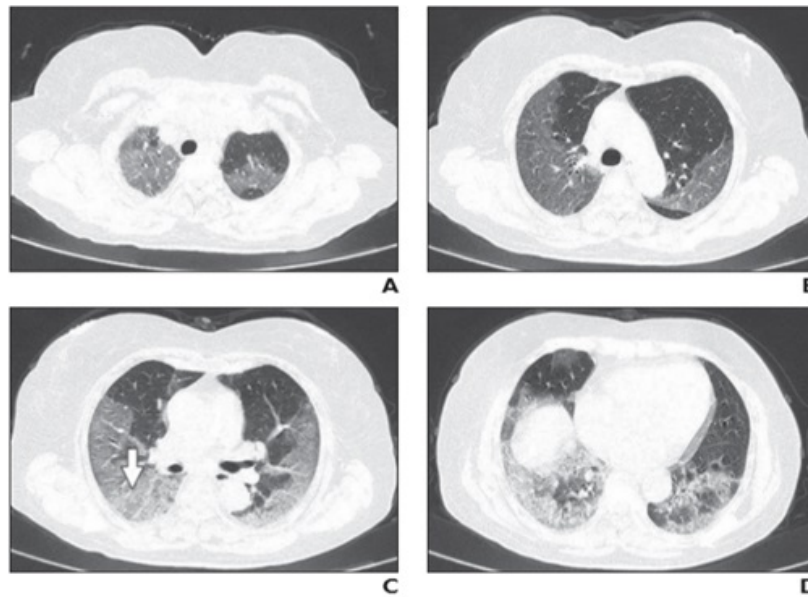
Chest CT findings accompanying severe COVID-19 disease diagnosed in a 63-year-old woman in Wuhan. She presented with fever and cough. One day after admission, bilateral GGO and reticulation pattern is seen on CT images (CT involvement score 18).
